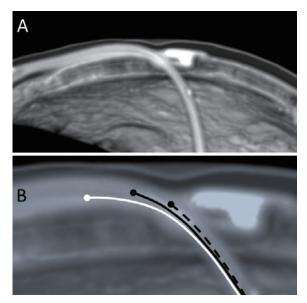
A: A cross-section including the shunt tube and skull of a 3D reconstructed image made from CT images taken 1 year after the first VPS surgery. B: Model of the process of shunt slipping in. The elasticity of the shunt tube exerts a force from the white line toward the black line, then from the black line toward the dashed black line.
